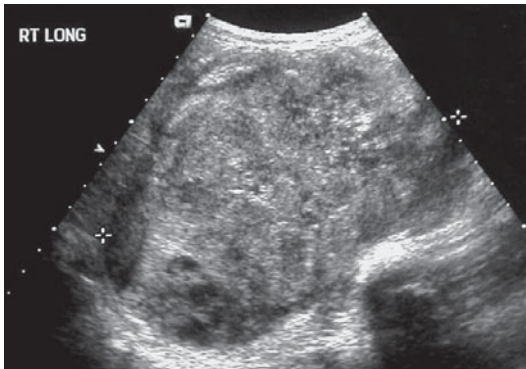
Ultrasonography. Nephroblastoma. Heterogeneous mass completely overrides the structures of the right kidney
